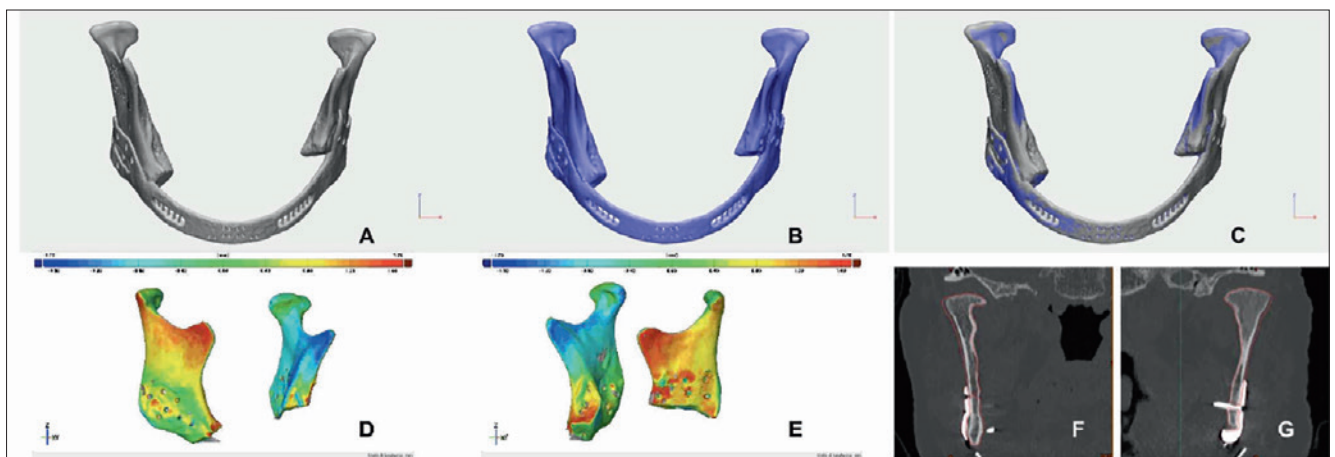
Post-operative accuracy evaluation. A: virtual planning; B: post-operative 3D CT-scan; C: superimposition of the virtual planning with the post-operative CT scan. D-E: error grade colour map. It provides a direct impression of the concordance between the pre-operative design and the post-operative position of the mandibular rami. F-G: CT-scan concordance between virtual planning (red line) and post-operative situation (coronal view).
